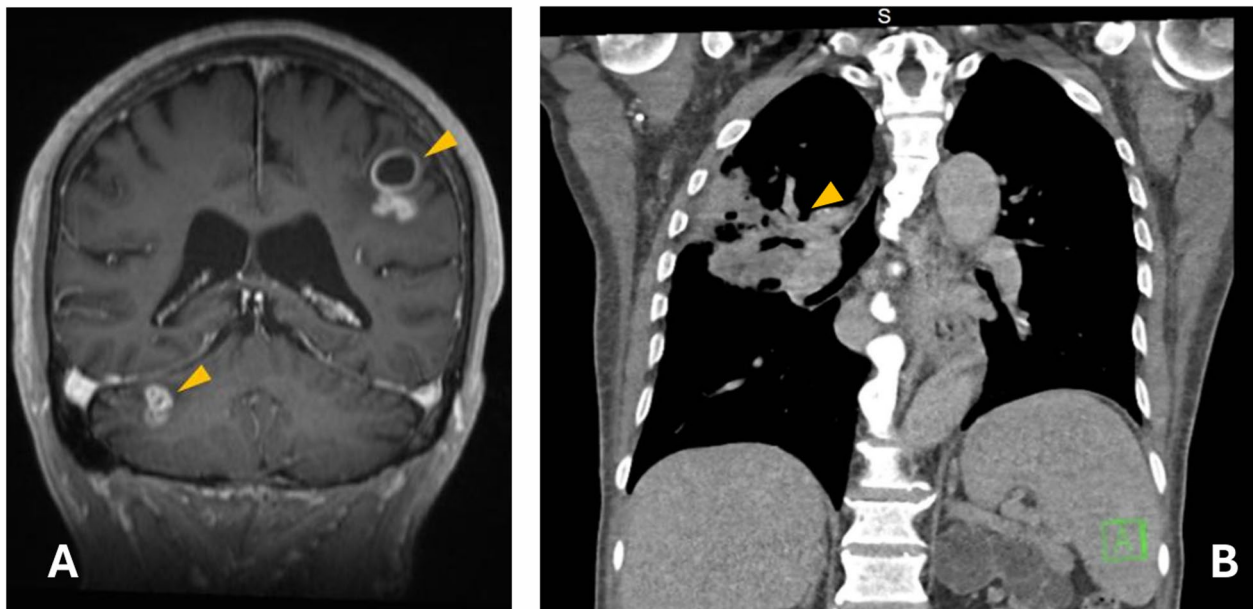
Admission brain and chest cross-sectional imaging. (A) Initial brain MRI scan (T1 weighted post gadolinium) showing both supra- and infratentorial ring-enhancing lesions suggestive of abscesses (yellow arrows); (B) Initial chest CT with portal venous iodinated contrast showing abscesses and cavitation (yellow arrows)
